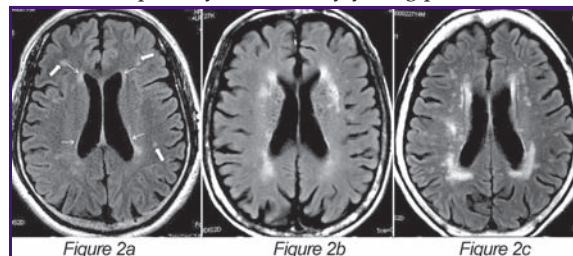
Axial FLAIR images demonstrate different grades of white matter hyperintensities (WMHs) in the brain. Figure 2a in a 55-year-old lady shows mild degree of WMHs with only a few punctate hyperintense lesions in the subcortical and deep white matters (bold arrow). The normal age-related periventricular hyperintense smooth thin rims as well as triangular-shaped “caps” around the frontal horns (short arrow) are also depicted. Figures 2b and 2c in two different elderly gentlemen in their seventies show moderate and severe degrees of WMH with patchy confluent WMHs in the deep and periventricular white matters, most obvious in the parietal lobes.
